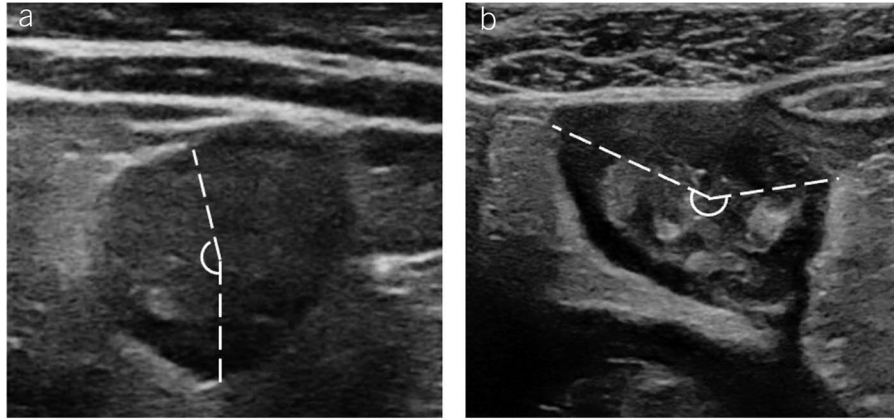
Creeping fat demonstration. On ultrasound, creeping fat is the hyperechoic sheets around the short axis of the intestine, and the wrapping angle is measured as presented. (a) creeping fat wrapping $<180^\circ$ and (b) creeping fat wrapping $>180^\circ$.
